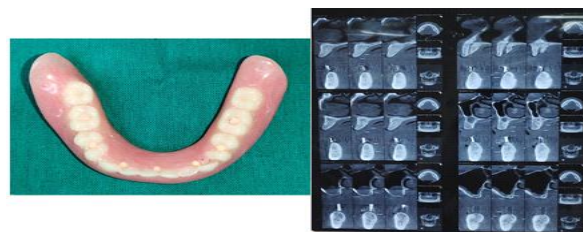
Existing mandibular complete denture modified with radiopaque markers and used as a radiographic template for prosthetically driven implant planning during CBCT evaluation.
